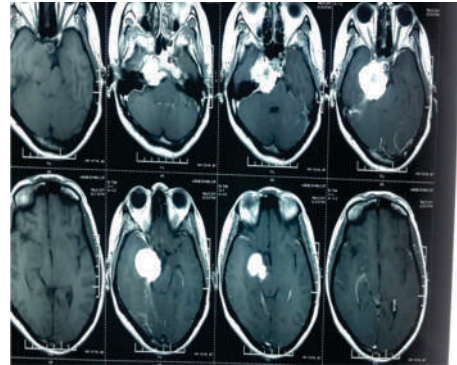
MRI brain showing CP angle tumour:
